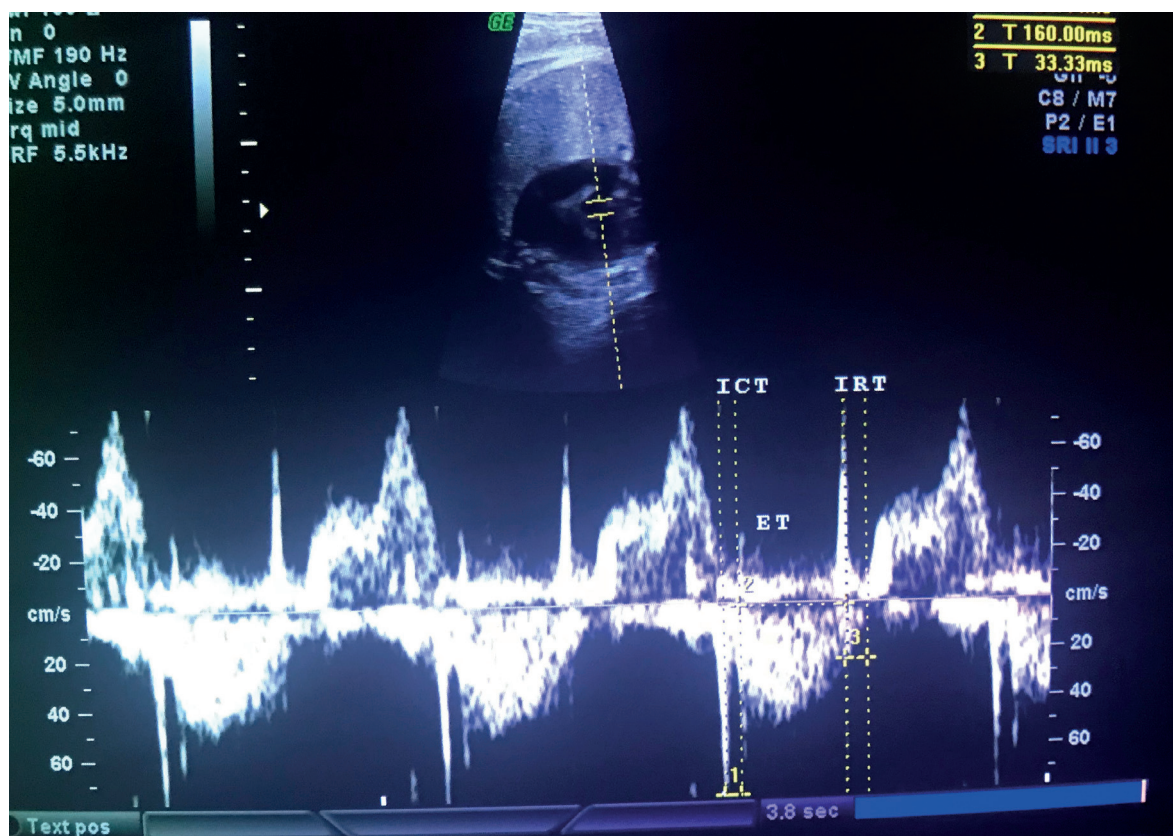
Doppler trace of isovolumetric contraction time (ICT), ejection time (ET), isovolumetric relaxation time (IRT), and E/A wave peak velocities.
